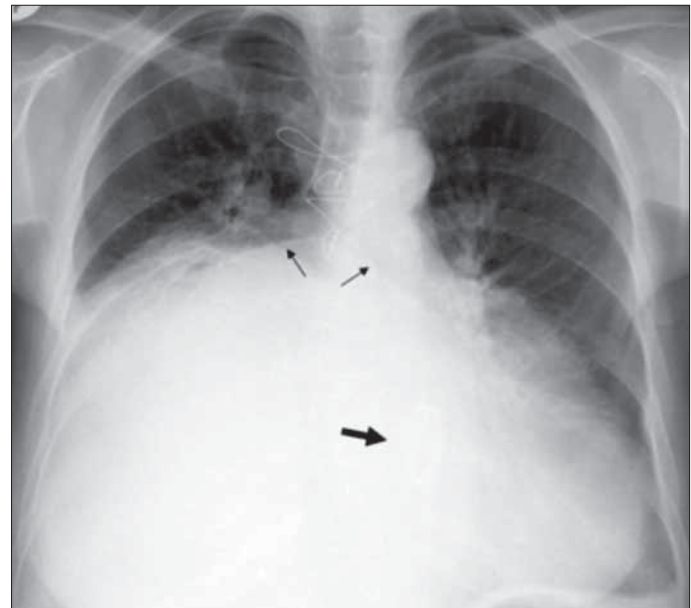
Postero-anterior chest radiography demonstrates gross cardiomegaly with right middle and lower lobe atelectasis. Subcarinal angle widened due to huge left atrial enlargement (small arrows). Mitral prosthesis valve (thick arrow) and postoperative changes are also seen
